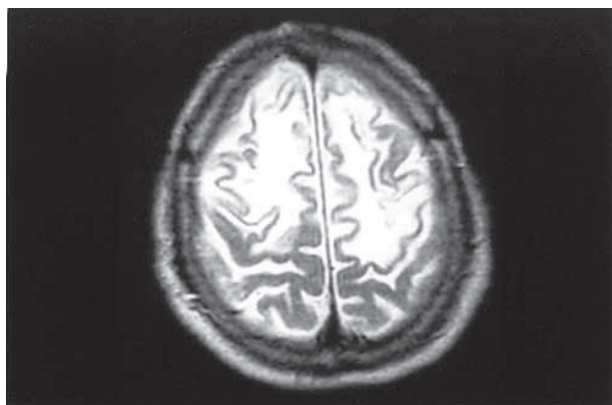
Diffuse frontal subcortical hyperintensity on T2 weighted MRI images.
